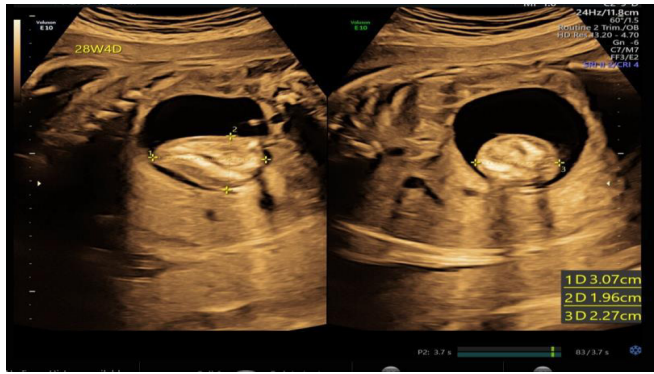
Prenatal ultrasound examination of the FIF at 26 weeks' gestation (left) and 22 weeks' gestation (right).
